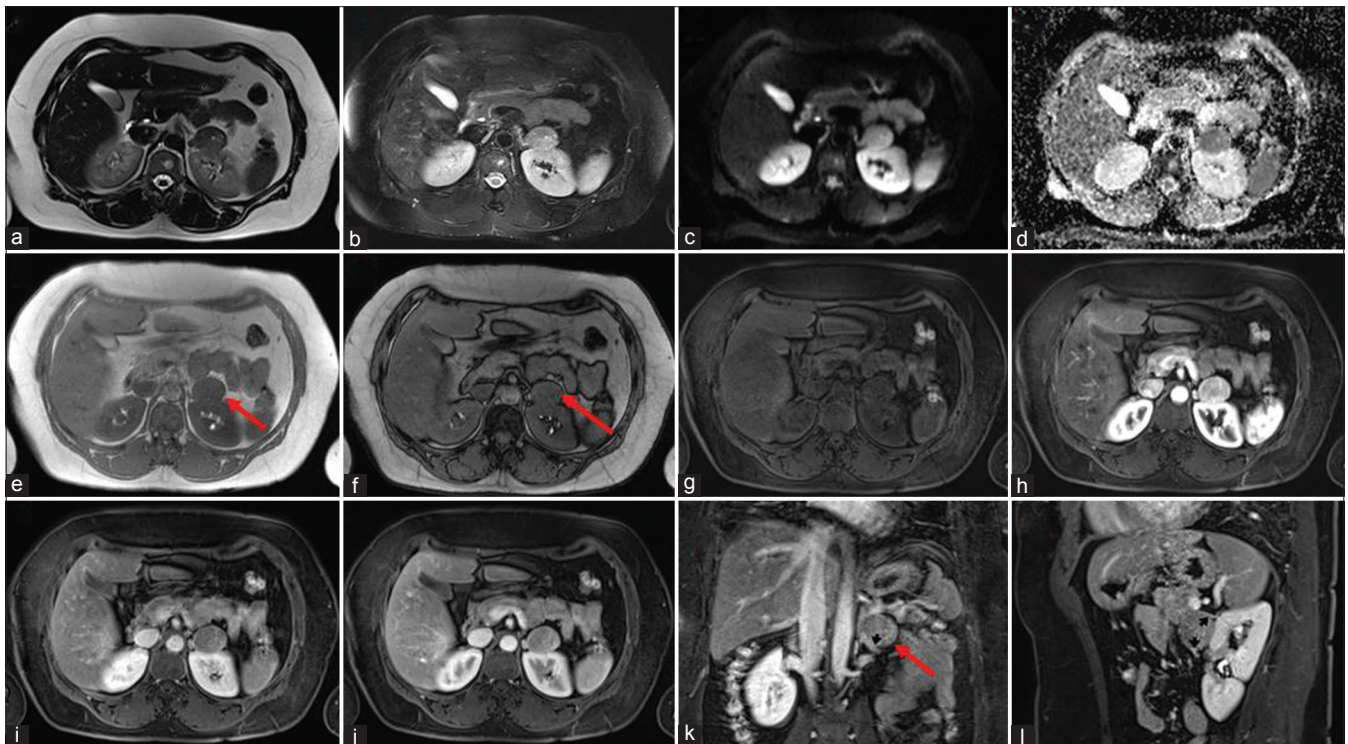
(a) Axial T2 half-Fourier acquisition single-shot turbo spin echo, (b) axial fat-saturated T2 fast spin echo, (c) axial diffusion, (d) apparent diffusion coefficient map, axial (e) in- and (f) out-of-phase T1 gradient echo, axial (g) pre- and postcontrast three-dimensional-gradient echo fat-saturated T1-weighted images during the (h) arterial, (i) portal venous, and (j) delayed phases, (k) coronal, and (l) sagittal postcontrast three-dimensional-gradient echo fat-saturated T1-weighted images
